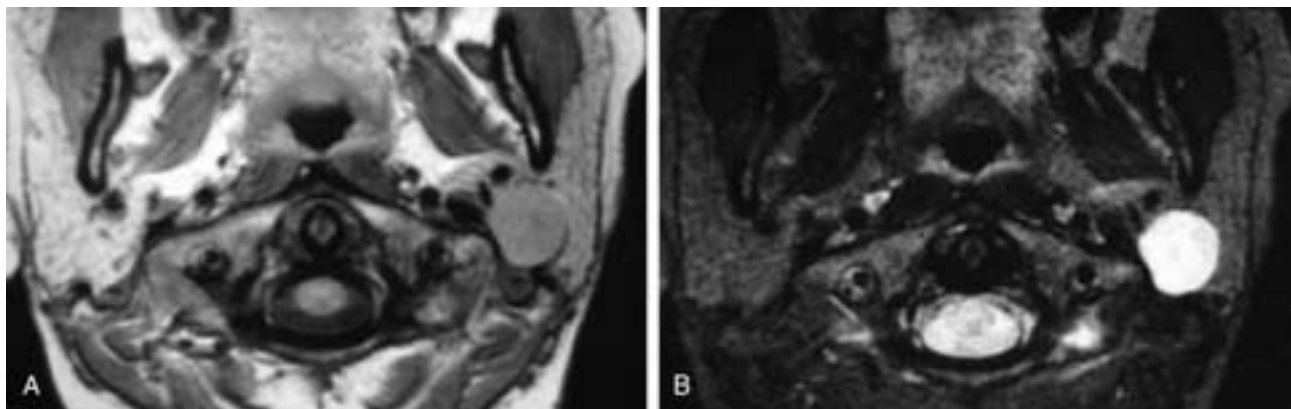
Axial T1-weighted (A) and T2-weighted (B) MR scans show a sharply defined mass in the posterior left parotid gland, along the course of the facial nerve. This is a nonspecific imaging appearance. This patient had a schwannoma of the facial nerve.
